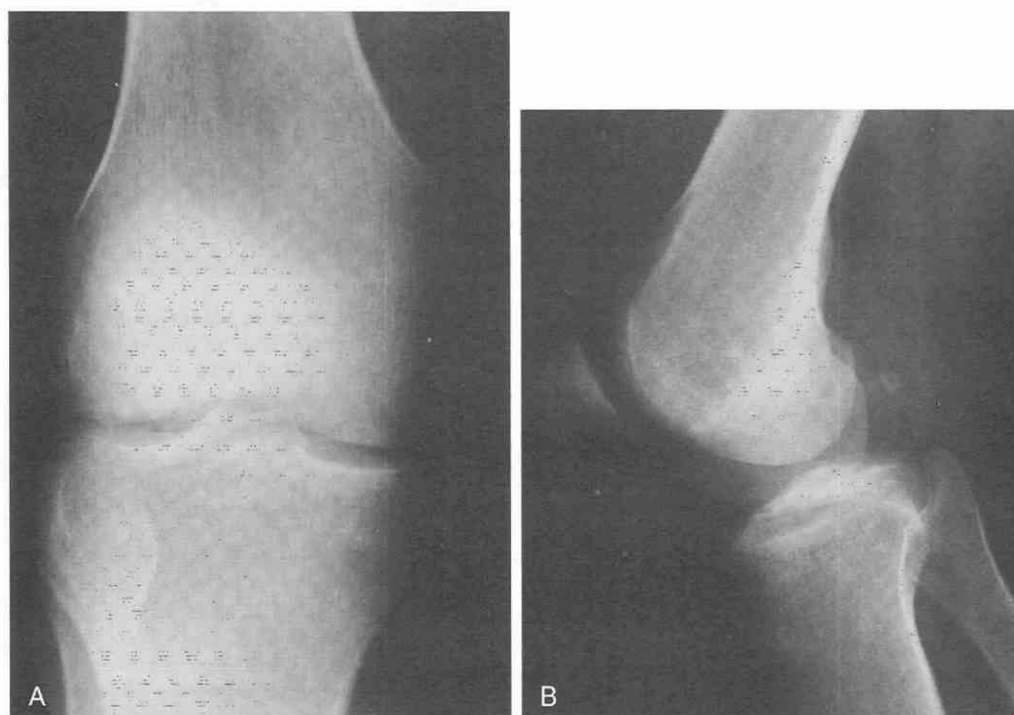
Lymphoma. A and B, Anteroposterior and lateral radiographs of the right knee are normal.
